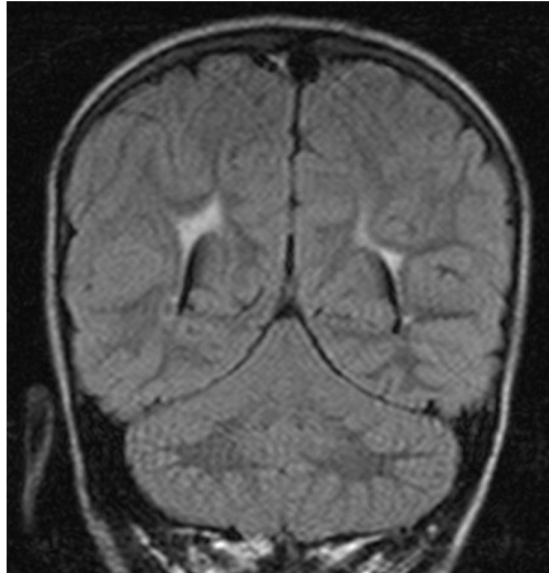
MRI Brain FLAIR Coronal showing bilateral Parieto-occipital
